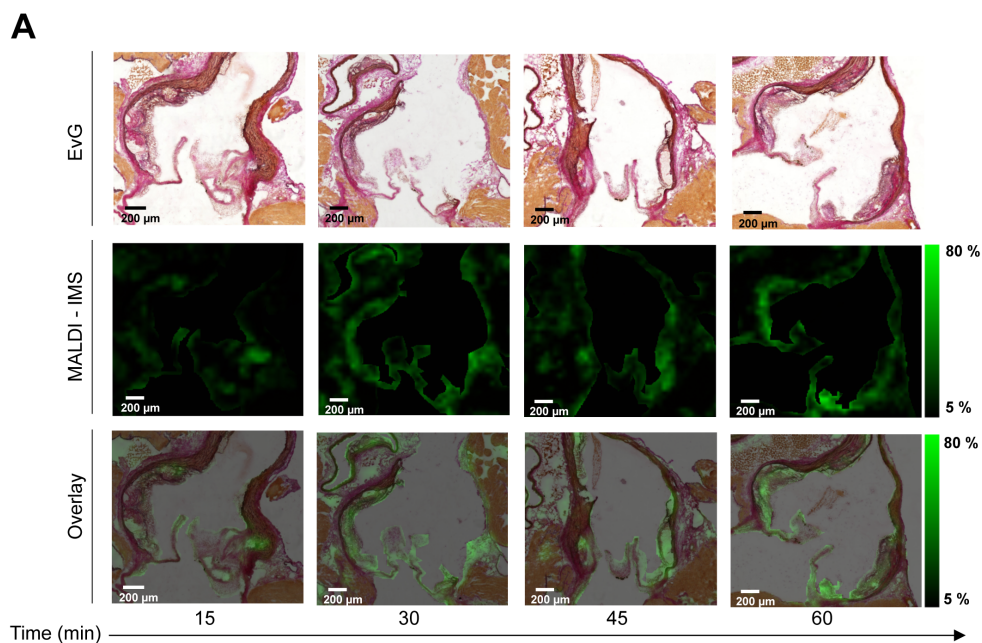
Kinetic study of contrast enhancement in atherosclerotic plaques. (A) Gadolinium enhancement represents contrast agent circulation after administration of Gadofluorine P (0.2 mmol/kg body weight) in the aortic arch. (B) In vivo MRI kinetic study of Gadofluorine P accumulation over a time period of 6h. R_1 values for atherosclerotic plaques, located in the aortic root, blood and skeletal muscle are presented (n=3; mean \pm SD).
